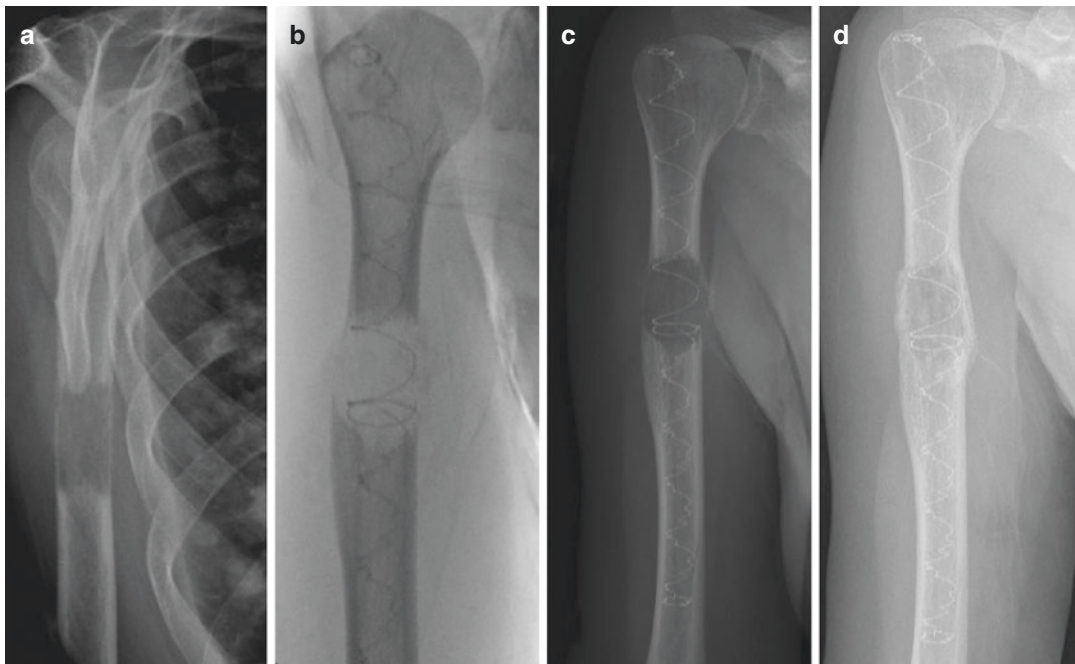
Clinical case of a patient with a pathologic fracture of the humerus due to a metastasis from a solid tumor (a), fluoroscopic intraoperative picture of the Illuminoss® implant (b); 1-week postoperative X-ray (c);
